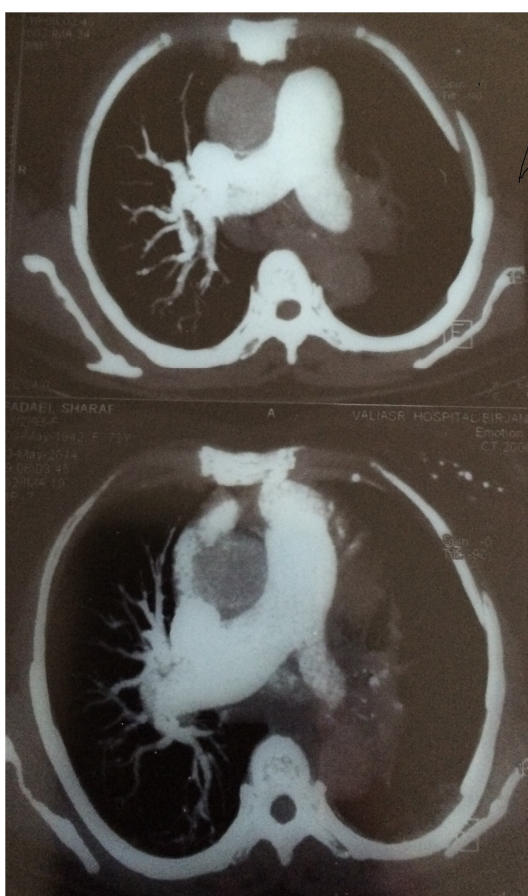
CT angiography of massive pulmonary embolism; LPA cut off due to deep vein thrombosis
